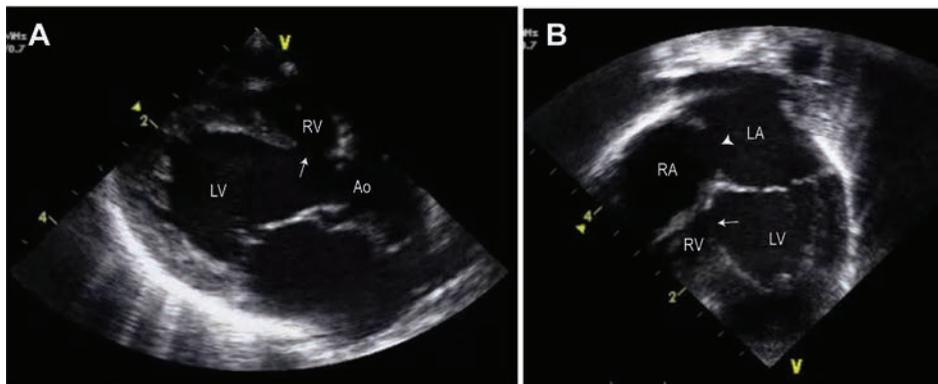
Parasternal long-axis (A) and 4-chamber (B) echocardiographic views of a patient with tricuspid atresia and normally related great vessels. There is no communication between the RA and the hypoplastic RV. A large ASD (arrowhead) and a large VSD (arrow) are visualized. Images courtesy of Dr. Josh Kailin, www.pedecho.org.
